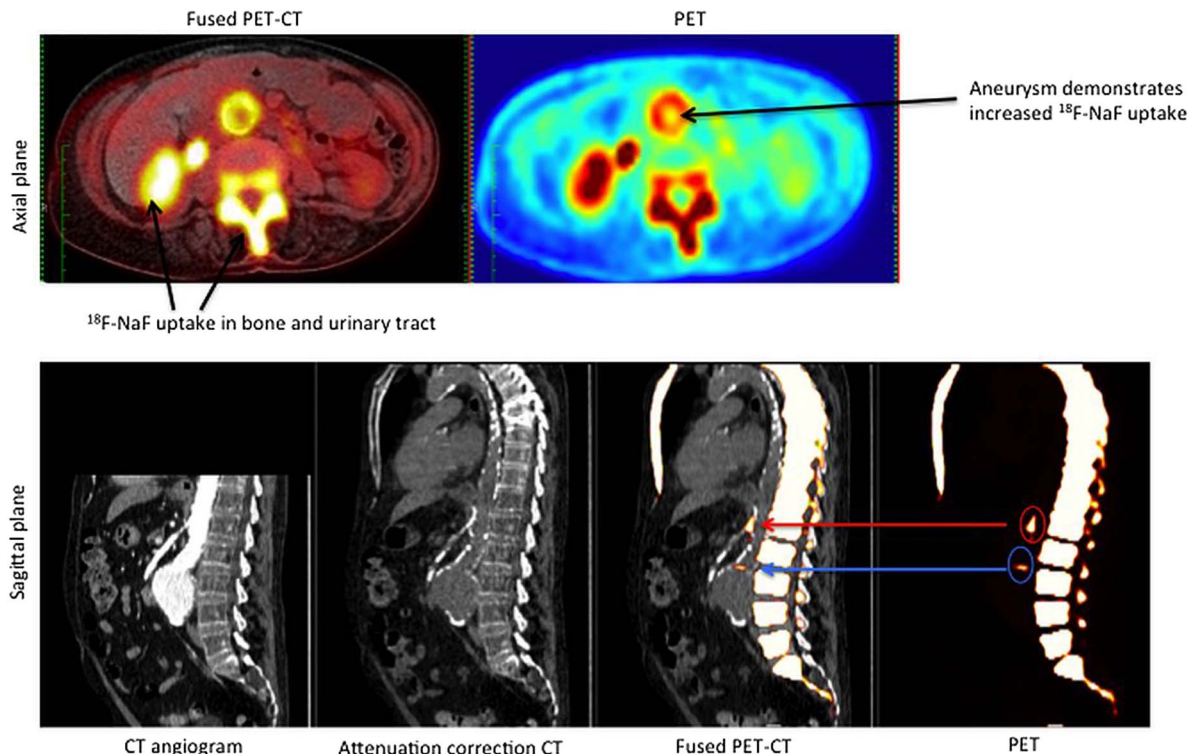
^{18}F -NaF positron emission tomography–computed tomography (PET-CT) in abdominal aortic aneurysm disease. This technique is currently being investigated in the SoFIA³ study (Sodium Fluoride Imaging (^{18}F -NaF PET-CT) in Abdominal Aortic Aneurysms—NCT02229006).
